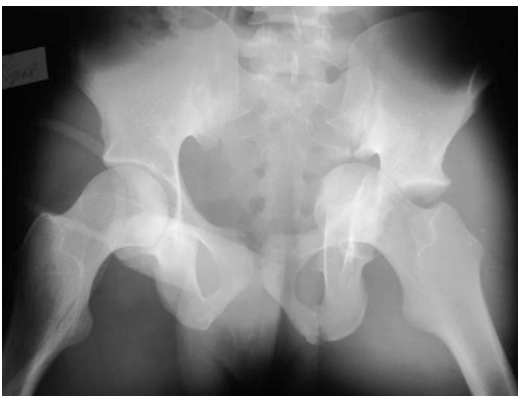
This T-type acetabular fracture with “central dislocation” occurred when the young motorcyclist’s leg was hit head on by another motorcyclist (*left*). The postreduction x-ray (*right*) without traction shows
